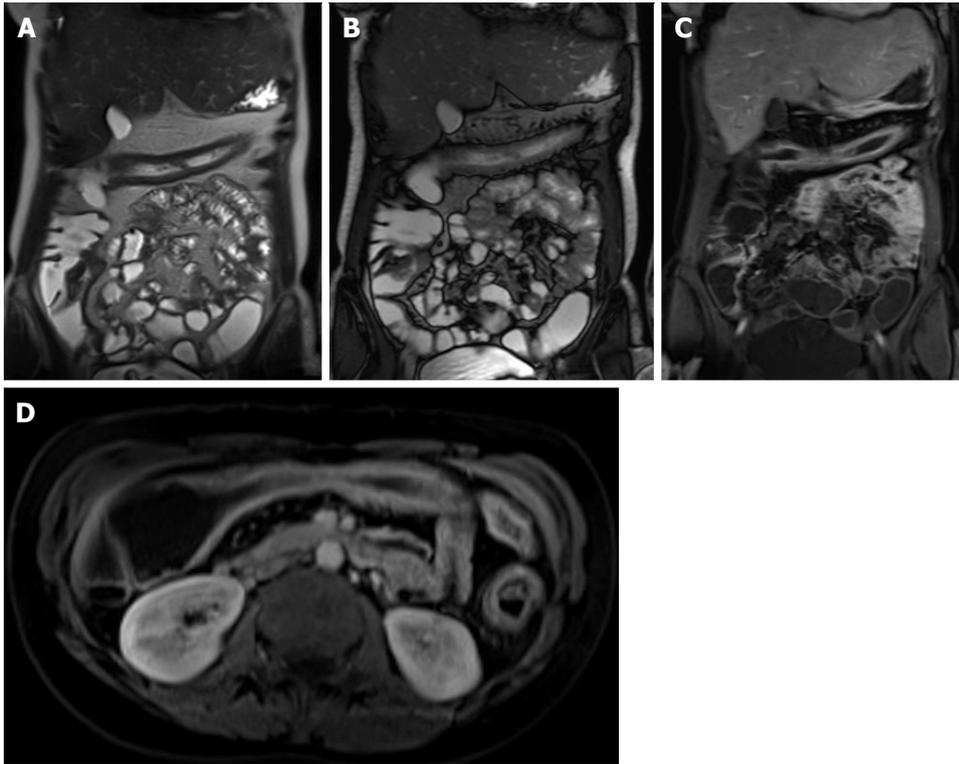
Crohn's colitis. A: Coronal T2-weighted single shot fast spin echo; B: Coronal balanced steady state free precession images; C: Coronal; D: Axial fat-suppressed post-gadolinium 3D-GRE T1-weighted images. There is a segmental uniform thickening of the transverse colon associated with submucosal edema (A and B), mucosal hyper-enhancement, and engorgement of the supplying mesenteric vessels (C and D) in keeping with active Crohn's colitis. Also of note is the focal hyper-enhancement of the terminal ileum (C). GRE: Gradient recalled echo.
